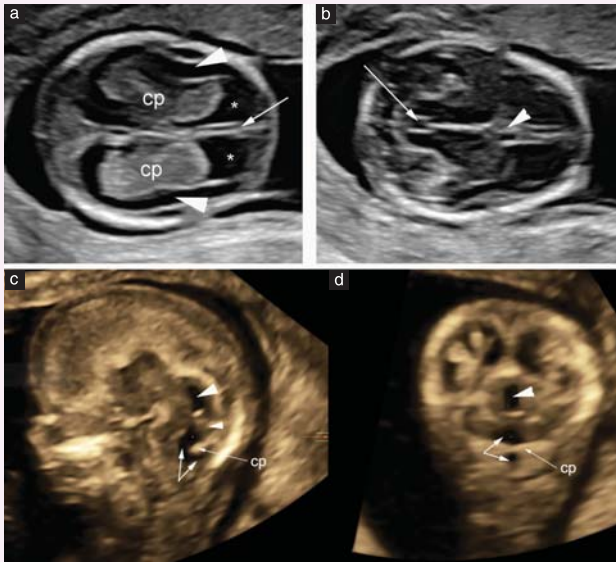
Neurosonography at 13 gestational weeks. (a) Transventricular axial plane, showing falx in midline (arrow) and ‘butterfly sign’ formed by prominent choroid plexuses (cp), with cerebrospinal fluid evident (*). Also, thin rim of developing brain parenchyma is visible as virtually anechoic strip of tissue (arrowheads), outlined by hyperechoic meninges on outer surface and by similarly hyperechoic ependymal lining medially. (b) Transthalamic axial plane. Plane cuts across diencephalon and prominent aqueduct (arrow). Falx is also evident anteriorly, as is very first hint of cavum septi pellucidum (CSP), appearing as irregularity of falx (arrowhead). It should be underlined that CSP is only evident in some cases, with high-frequency transducers. (c,d) Midsagittal and posterior coronal planes are better visualized if reconstructed from three-dimensional volume acquired transvaginally, due to obvious need for multiplanar image correlation. (c) Structures that can be recognized in reconstructed midsagittal plane: prominent aqueduct of Sylvius (large arrowhead), typical of this gestational age; hypoechoic diencephalon, in front of aqueduct; posterior fossa, with continuity between fourth ventricle and physiologic Blake’s pouch (double arrow). Hyperechoic choroid plexus (cp) of fourth ventricle is visible between fourth ventricle and Blake’s pouch, with vermian (small arrowhead) above. (d) On reconstructed posterior coronal plane, at level of aqueduct of Sylvius, aqueduct is seen clearly (arrowhead). Below, fourth ventricle and Blake’s pouch (double arrow) are separated by choroid plexus of fourth ventricle (cp).
